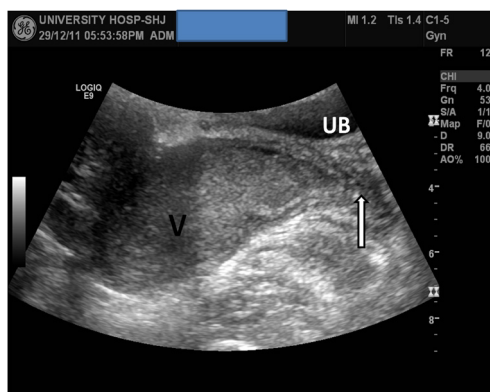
Sagittal transabdominal pelvic ultrasound showing dilated left vagina with debris "V", and the level of the distal left vaginal obstruction "long arrow". UB: urinary bladder.
